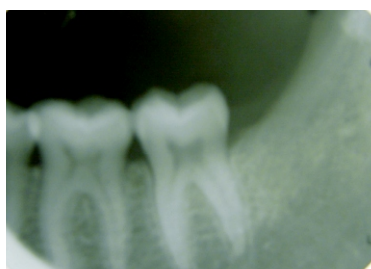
Post operative (6 months) radiograph of graft site
